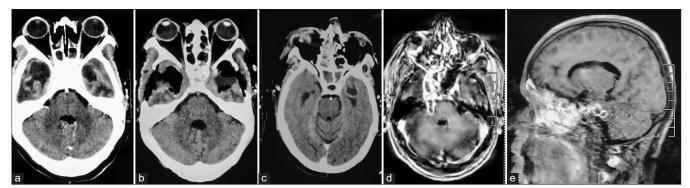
(a and b) Preoperative and postoperative computed tomography (CT) scan images of the brain showing complete excision of bilateral temporal lobe abscesses. (c) CT scan image of the brain depicting left medial temporal lobe abscess. (d and e) In a case of rhinoorbito-cerebral mucormycosis (ROCM) with radiology which is suggestive of the involvement of all sinuses (pansinusitis), in the brain, a lesion is seen involving the right cavernous sinus and right medial temporal lobe with extension into the right cerebellopontine angle.
